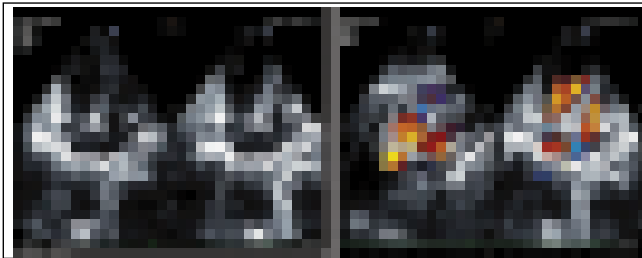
Echocardiography demonstrates supra cardiac TAPVC
